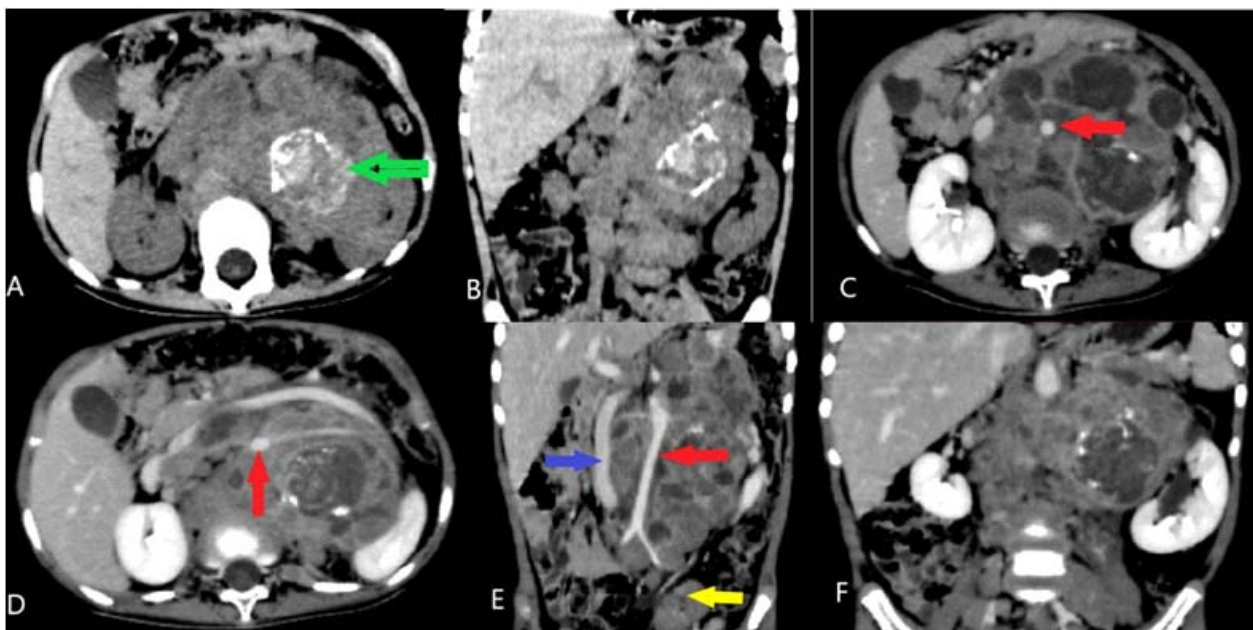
(A & B) Axial & coronal non-enhanced abdomen CT scan showing ill defined lobulated heterogenous solid-cystic lesion in retroperitoneum in the left suprarenal region showing multiple areas of calcification (Green arrow); (C & D) Axial enhanced abdomen CT scan showing heterogeneous enhancement of the lesion and anterior displacement of abdominal aorta (Red arrow); (E) Coronal enhanced abdomen CT scan showing encasement of abdominal aorta (Red arrow), right lateral displacement of Inferior vena cava (Blue arrow), Heterogeneously enhancing lymph node (Yellow arrow); (F) Postcontrast coronal image showing the lesion is crossing the midline.
